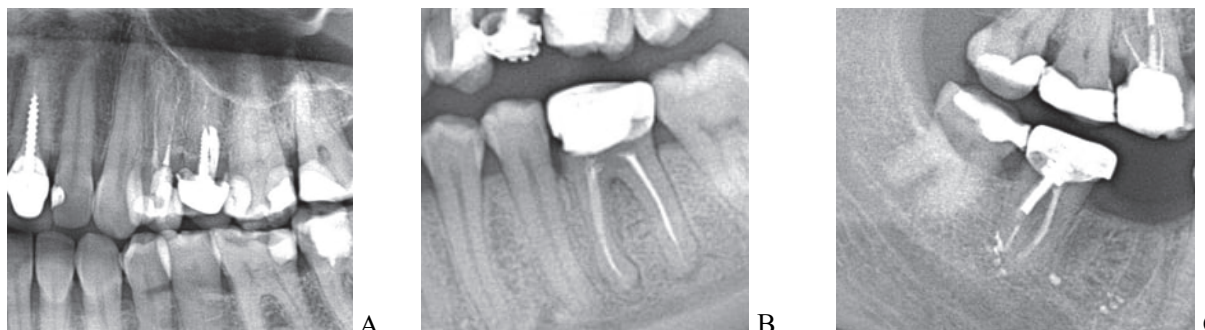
Fragments of orthopantomograms of patients with hypercementosis of teeth 24 (a), 36 (b), and 48 (v); photographs from the authors' personal archive.
